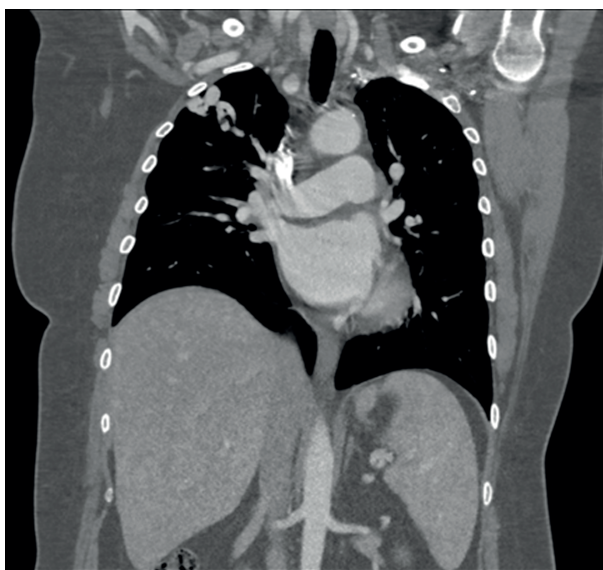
Coronal reformatted image of the chest CT after administration of intravenous contrast material. Dilated vascular structure (arrow) in the right upper lobe.
